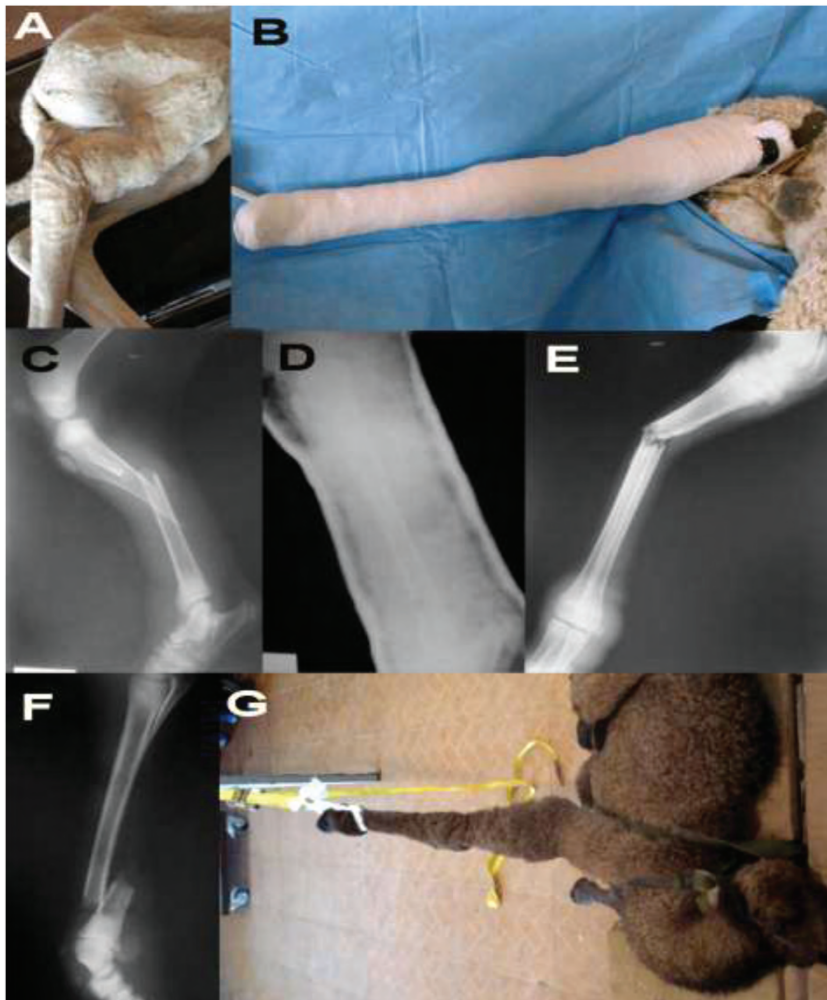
Young camel with closed tibial fracture (A), a cast of plaster of paris bandage with 2 PVC splints for a tibial fracture (B), lateral radiographs of an oblique tibial fracture before treatment (C) and after treatment by plaster of paris cast (D), lateral radiographs of metatarsal (E) and radial (F), and the use of the ratchet tie down for closed reduction of radial fracture in a young camel (G).
